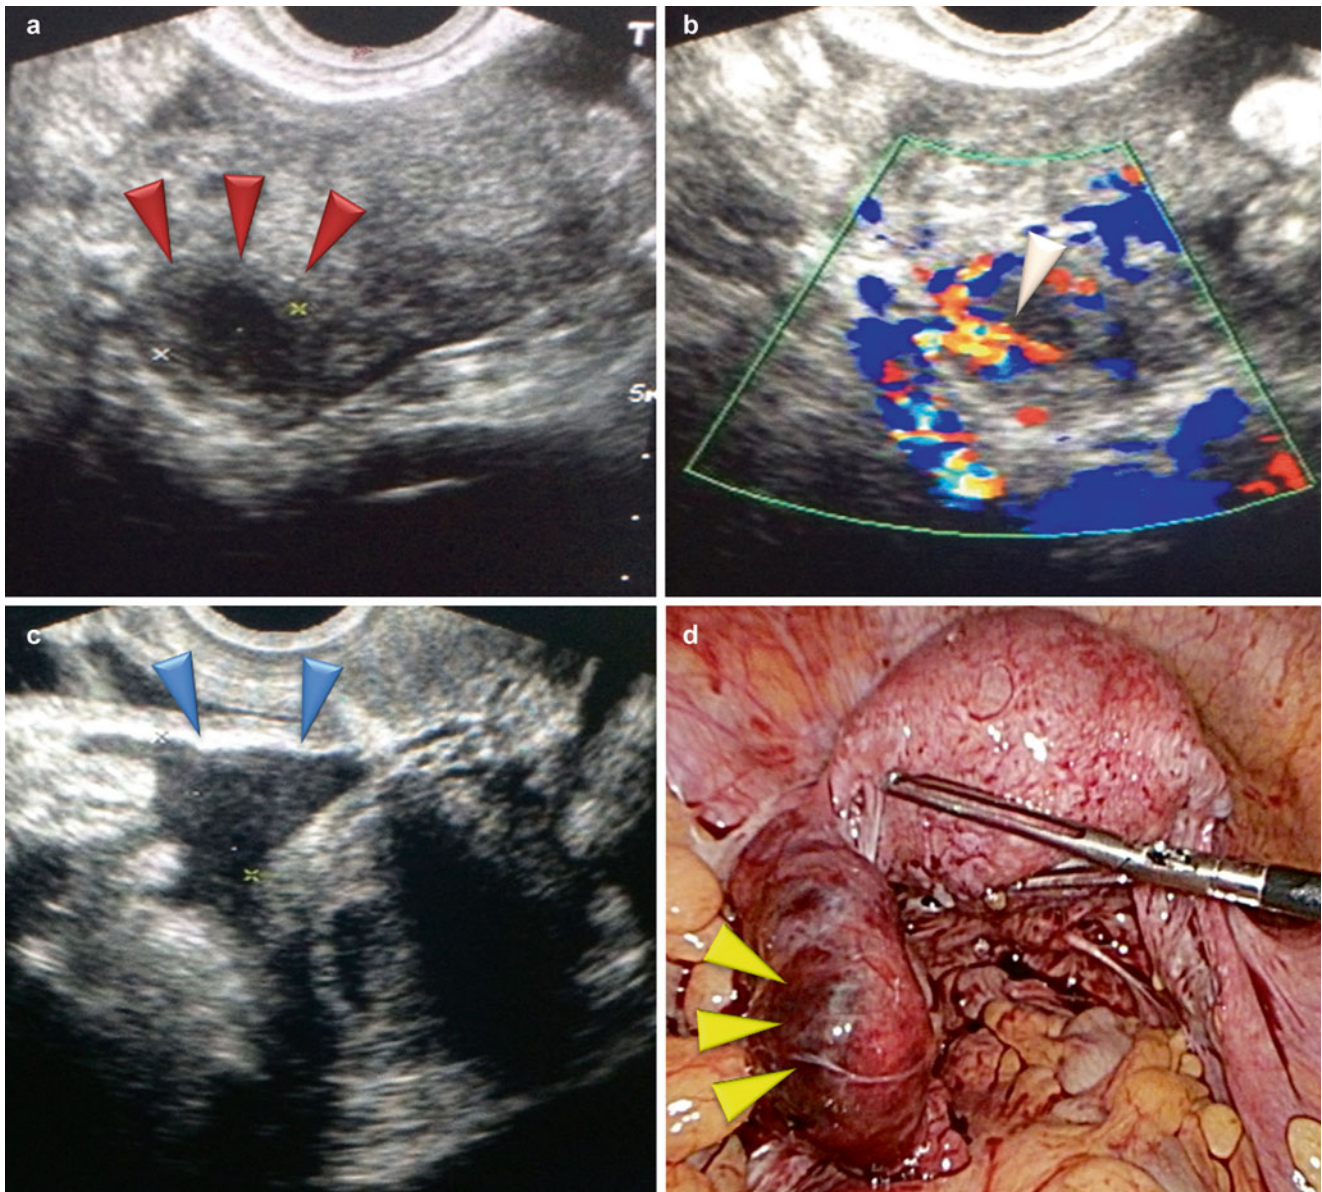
Left tubal ampullary pregnancy. Ultrasonography revealing a low echoic cystic mass (*red arrowheads*) on left adnexal area (a). Color Doppler ultrasonography revealing blood flows (*white arrowhead*) in a fetus-like lesion inside the cystic mass (b). Echo-free space
